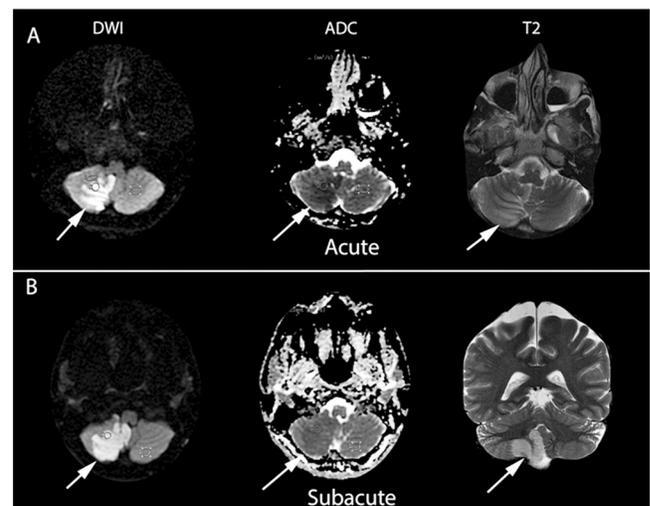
MRI findings in acute and subacute strokes. (A) During acute stroke, infarct regions appear hyperintense on diffusion-weighted imaging, and hypointense on ADC maps (white arrows); they are invisible in T₂-weighted images and Flair during the first 12 h, although some regions of acute infarct might start being noticeable in T₂-w in the 12-24 h period, as in this case. (B) Same patient as in A, imaged in the early subacute period; DWI might increase a little. Although the ADC map depicts the return of diffusion values to normal, T₂-w clearly demarcates the extension of the brain infarct (white arrow).
